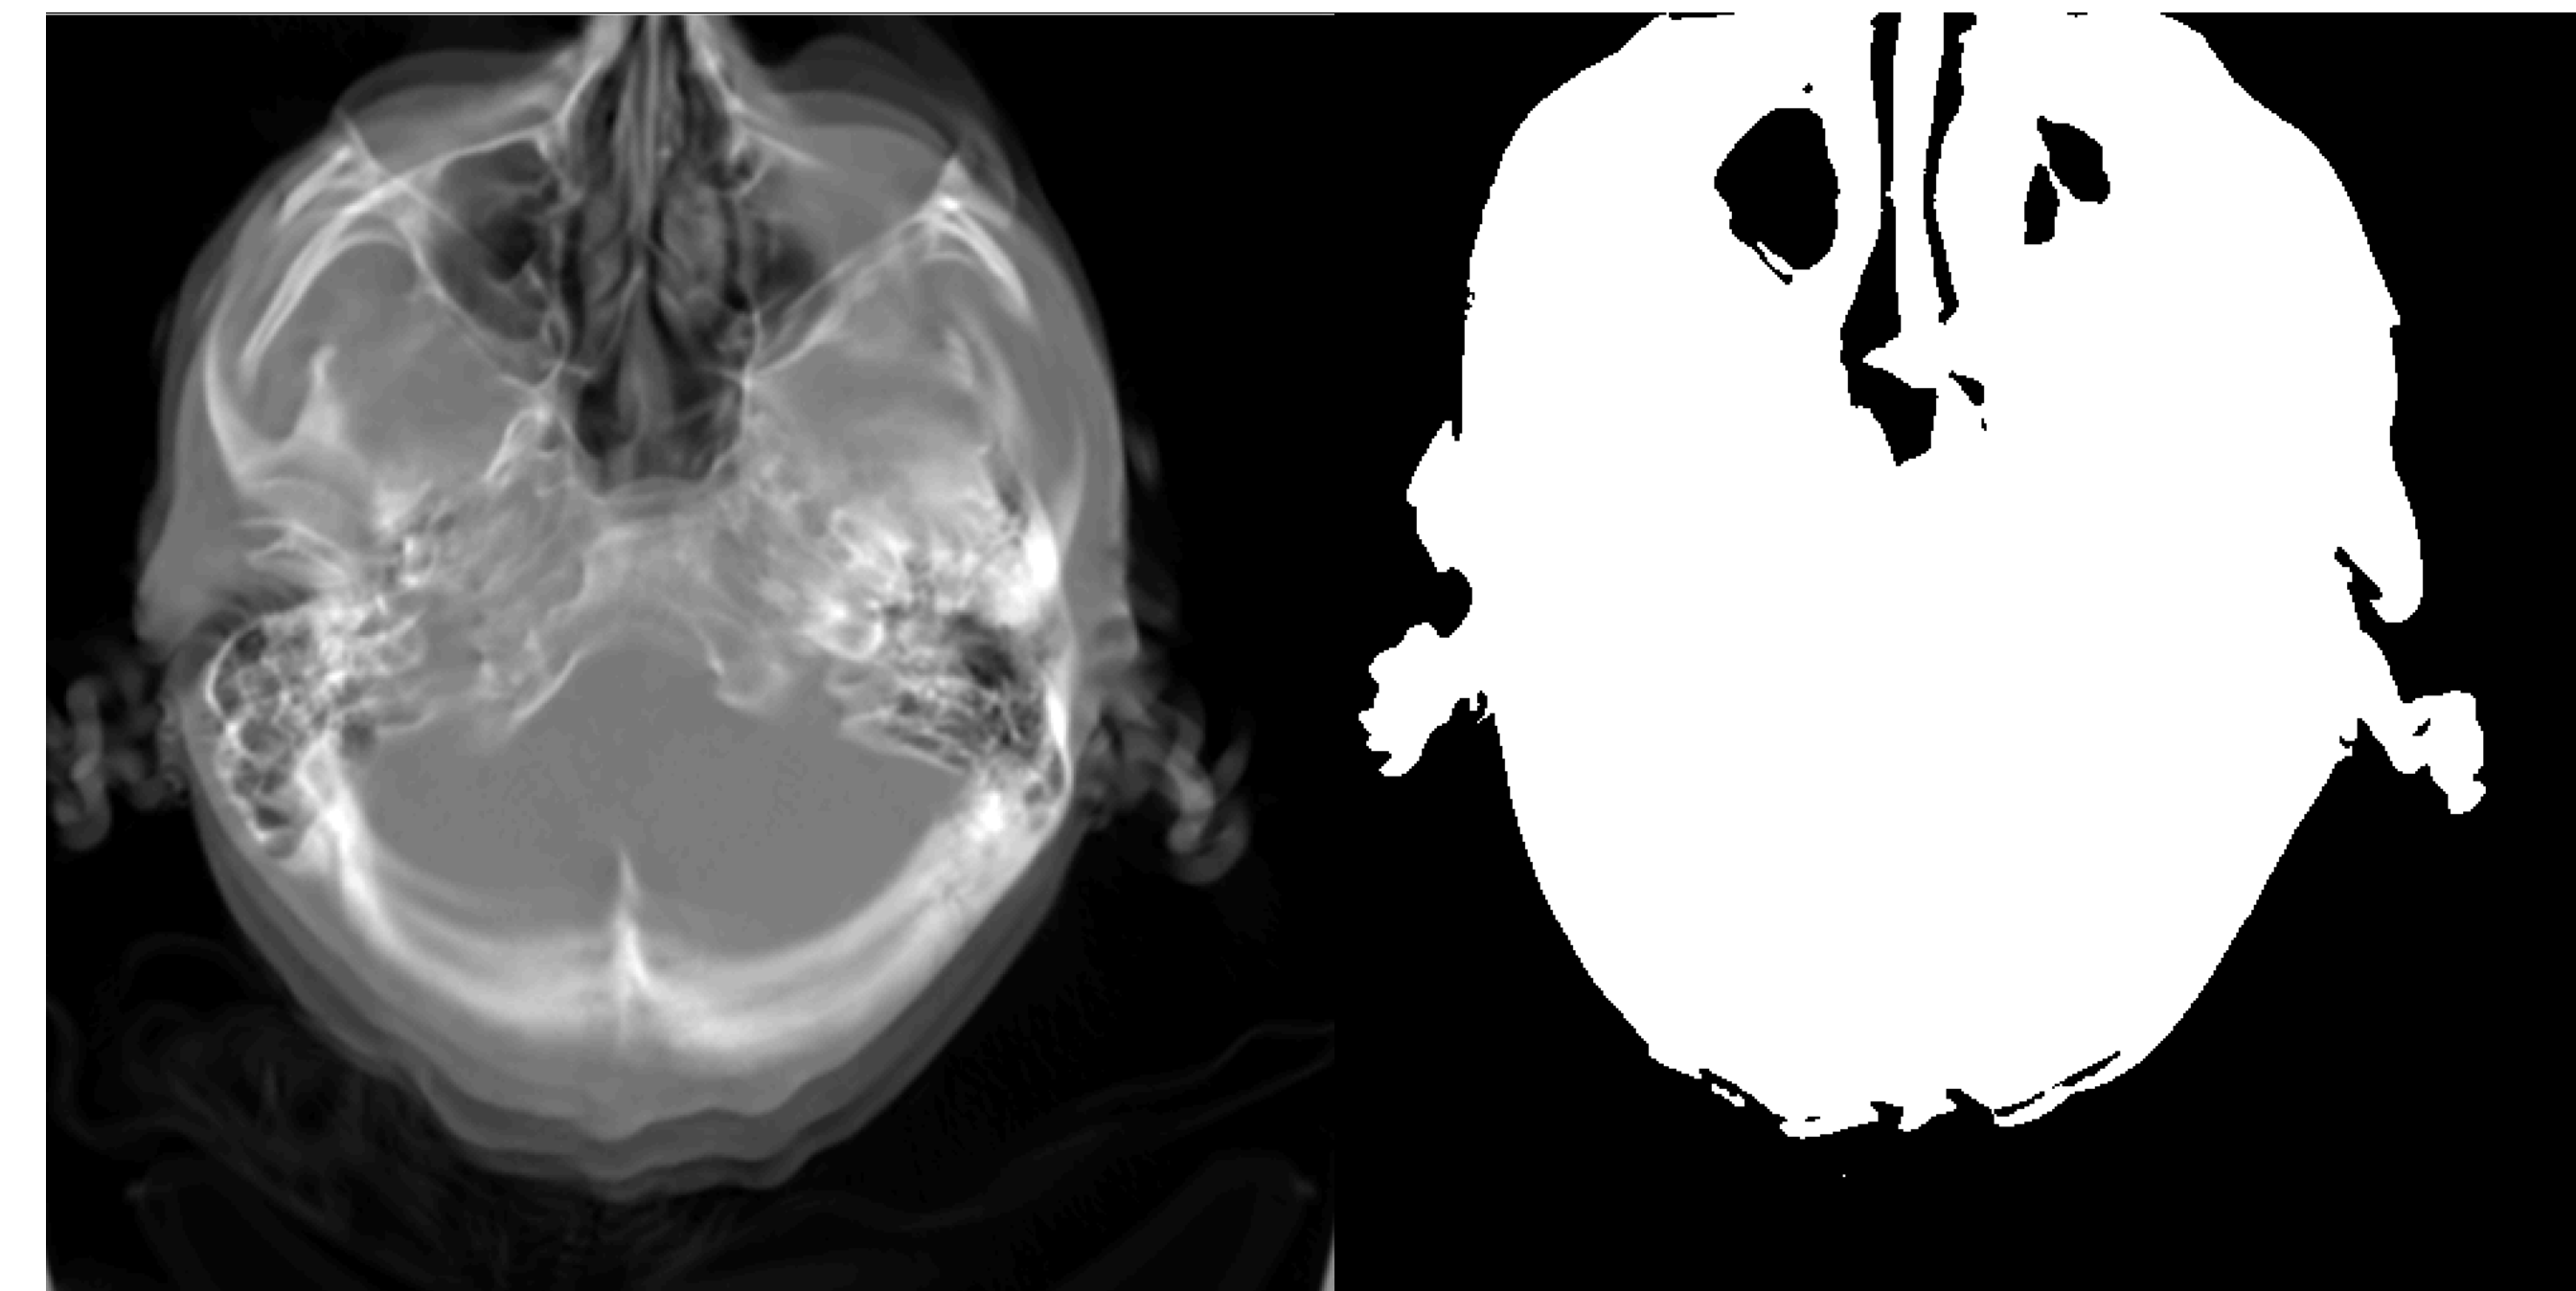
Example of a CT image slice (left) and its corresponding binary motion mask (right).
